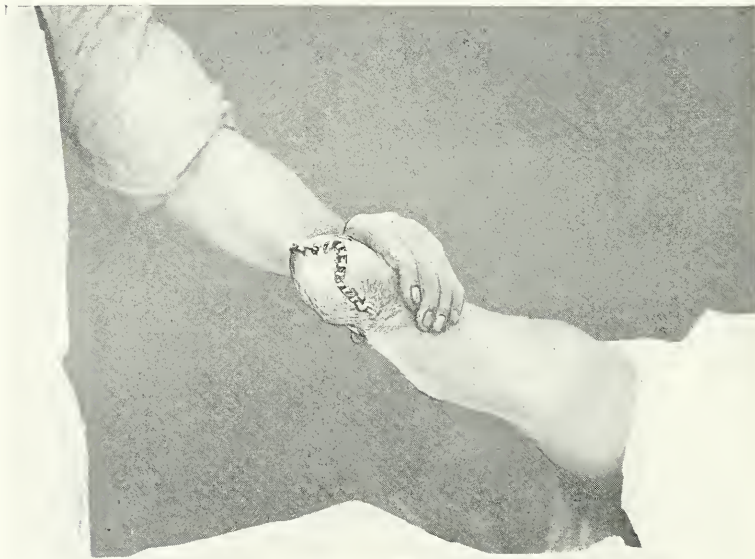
THE SAME. ASPECT OF THE SUTURES.
